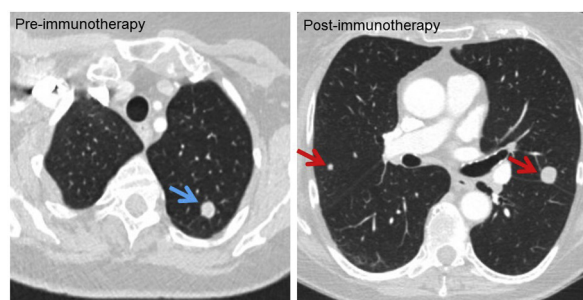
CT scan of the chest with contrast pretreatment. Blue arrow shows original rounded metastatic lesion. Postimmunotherapy CT imaging after 4 cycles of pembrolizumab. Red arrows show new pulmonary metastases.
